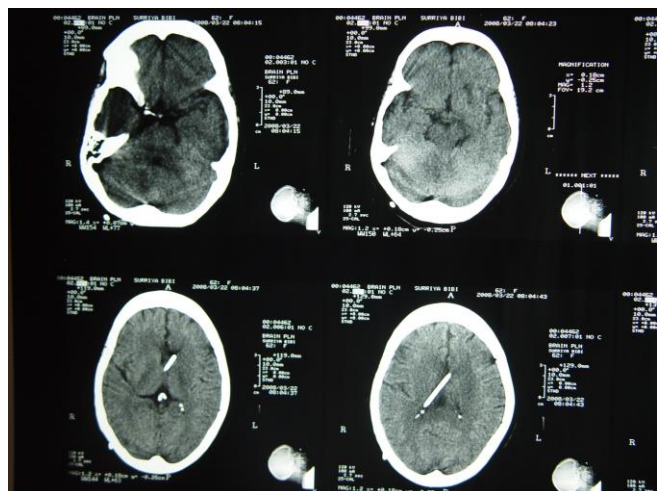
a: Postoperative CT Scan brain showing V. P Shunt insitu Cerebellar haematoma resolved with no obstructive hydrocephalus.
